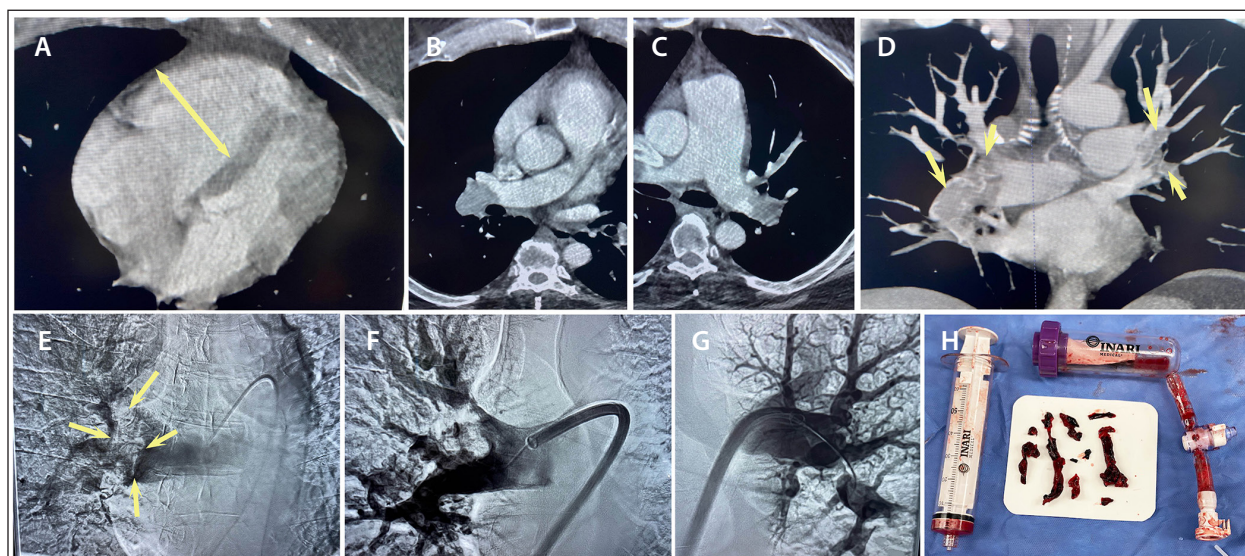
A CT scan showed evidence of right ventricular (RV) enlargement and right heart strain (A). CT pulmonary arteriography in axial view demonstrated thrombus in the right (B) and left (C) pulmonary arteries. The coronal view showed thrombus in the left and right pulmonary arteries (D). Limited pulmonary arteriography demonstrated thrombus in the right lower lobe (E). A 24-F Trier24 aspiration catheter was advanced to the right interlobar pulmonary artery, where the first aspiration was performed (F). Following several aspirations on the right, the Trier24 was advanced into the truncus anterior and left pulmonary artery branches for additional aspirations (G). Extracted thrombus is shown alongside the FlowSaver Blood Return System and a 60-mL large-bore syringe (H).
